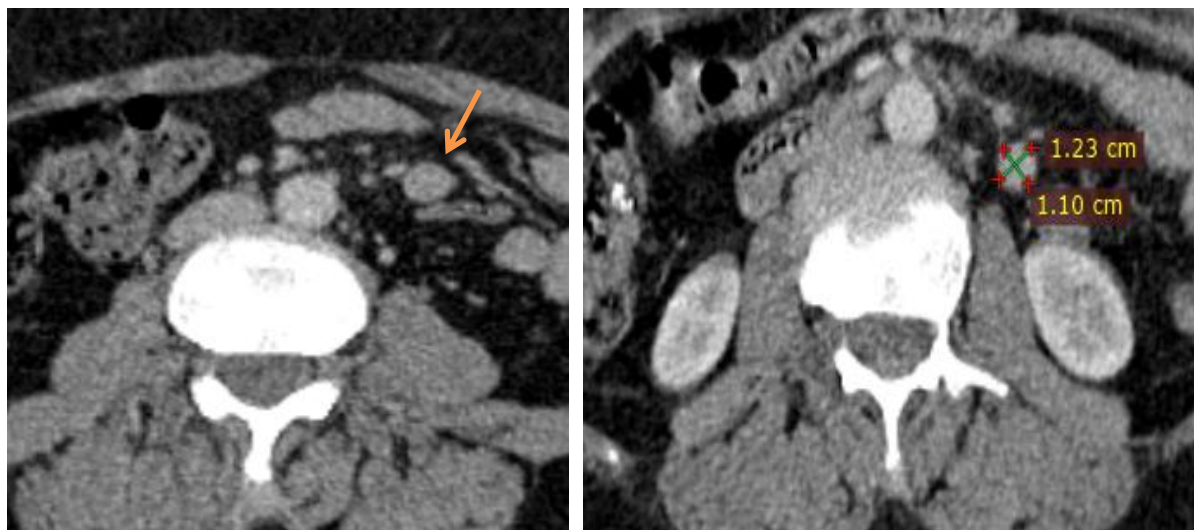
Initial CT appearance of the lesion. Contrast-enhanced CT obtained on August 28, 2024, showing a small, well-defined nodular lesion measuring 12.8×11.0 mm in the left para-aortic region, adjacent to the left kidney (arrow), initially interpreted as lymphadenopathy in the context of the patient's known breast carcinoma.
